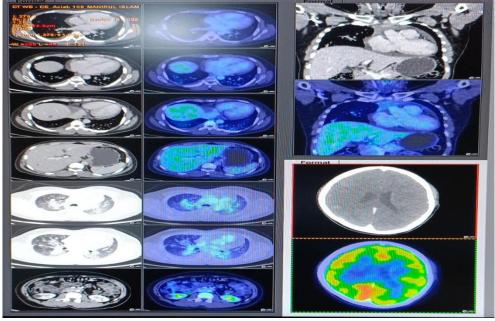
PET CT imaging showing near complete resolution of primary lesion and metastatic lesion in brain on follow up post treatment
